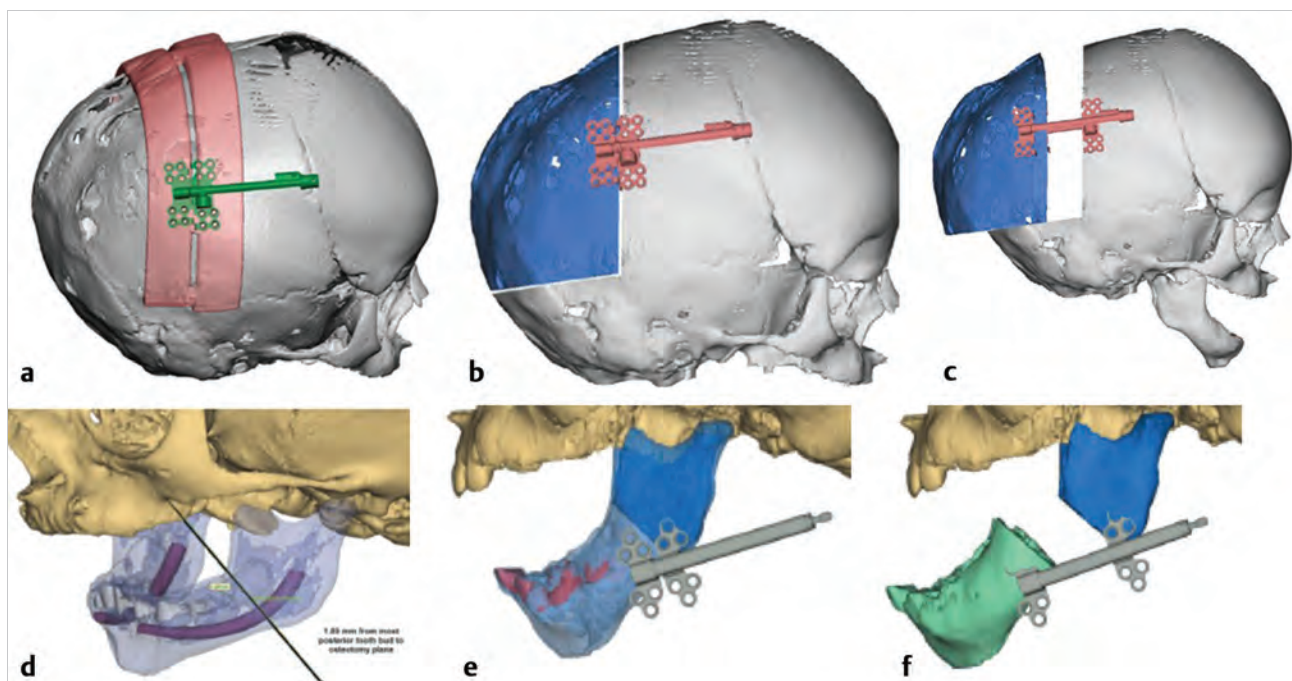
Three-dimensional plans from CT scans utilized in posterior vault distraction. (a–c) Computed tomographic images can be used to assess bony, soft tissue, and intracranial anatomy and print custom cutting guides to precisely and efficiently affect the surgical plan in the operating room. In mandibular distraction, the course of the inferior alveolar nerve and tooth buds can be analyzed with imaging to assist surgical planning (d–f).
